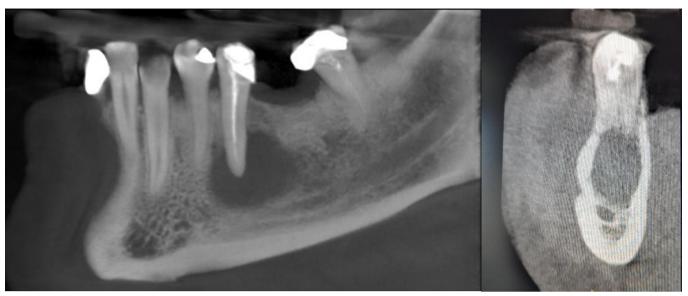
Pretreatment CBCT demonstrating a large cyst associated with the premolar that had prior Endodontic treatment.
